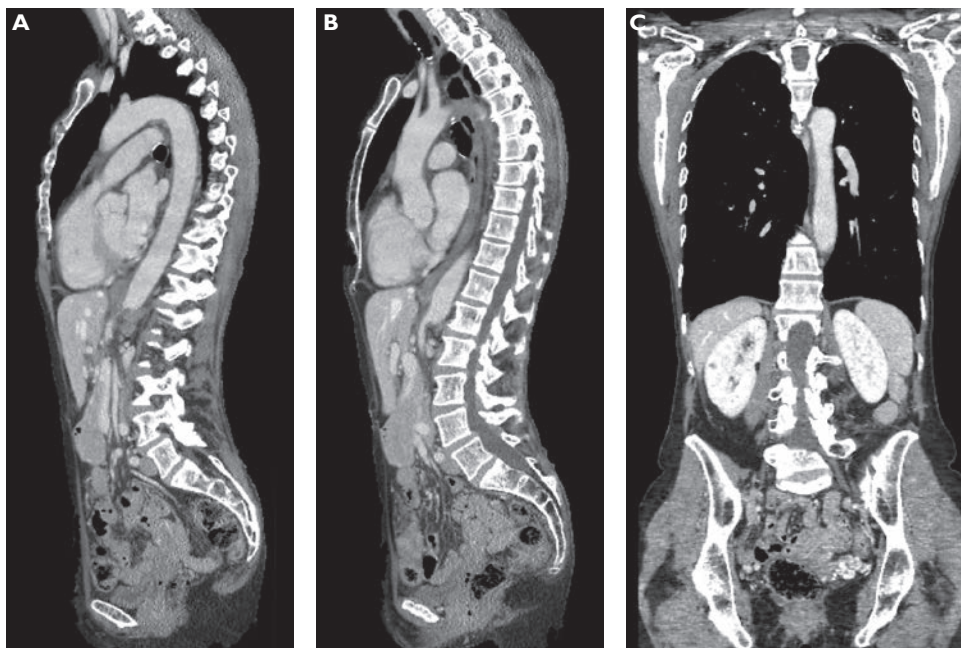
Subsequent computed tomography scans in the sagittal (A and B) and coronal (C) planes in the venous phase showed a lesion of the vaginal pertaining with ill-defined margins and inhomogeneous contrast-enhancement without clear planes of cleavage with the surrounding perineal muscles; no distant secondary lesions were evident.
